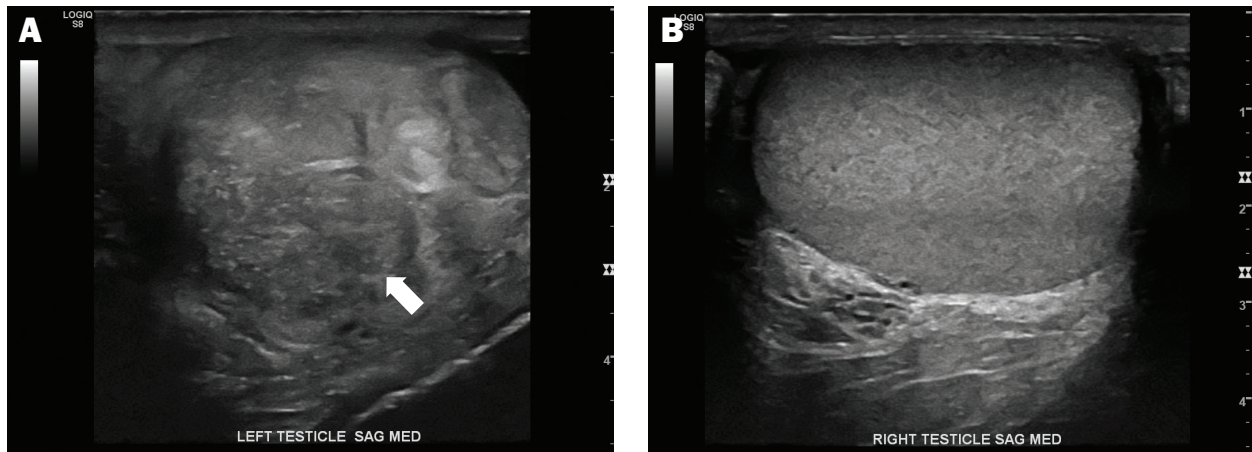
In an ultrasonogram, (A) the left testicle measures $4.8 \times 3.7 \times 3.3$ cm, with left testicular heterogeneity (yellow arrow); (B) the right testicle measures $4.3 \times 2.9 \times 3.5$ cm.
